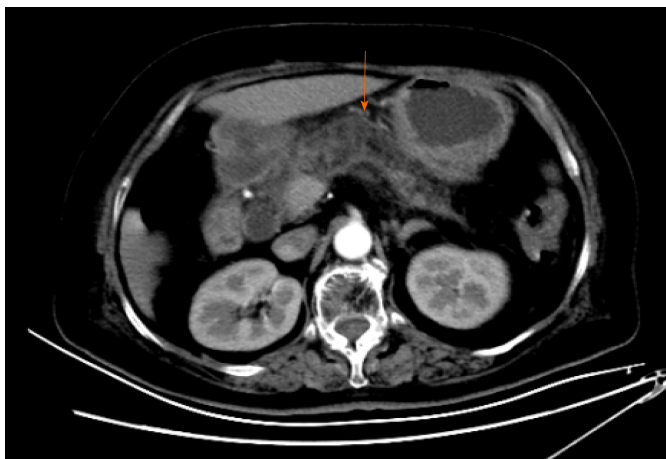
Abdominal computed tomography revealed mild inflammation of the pancreas.
